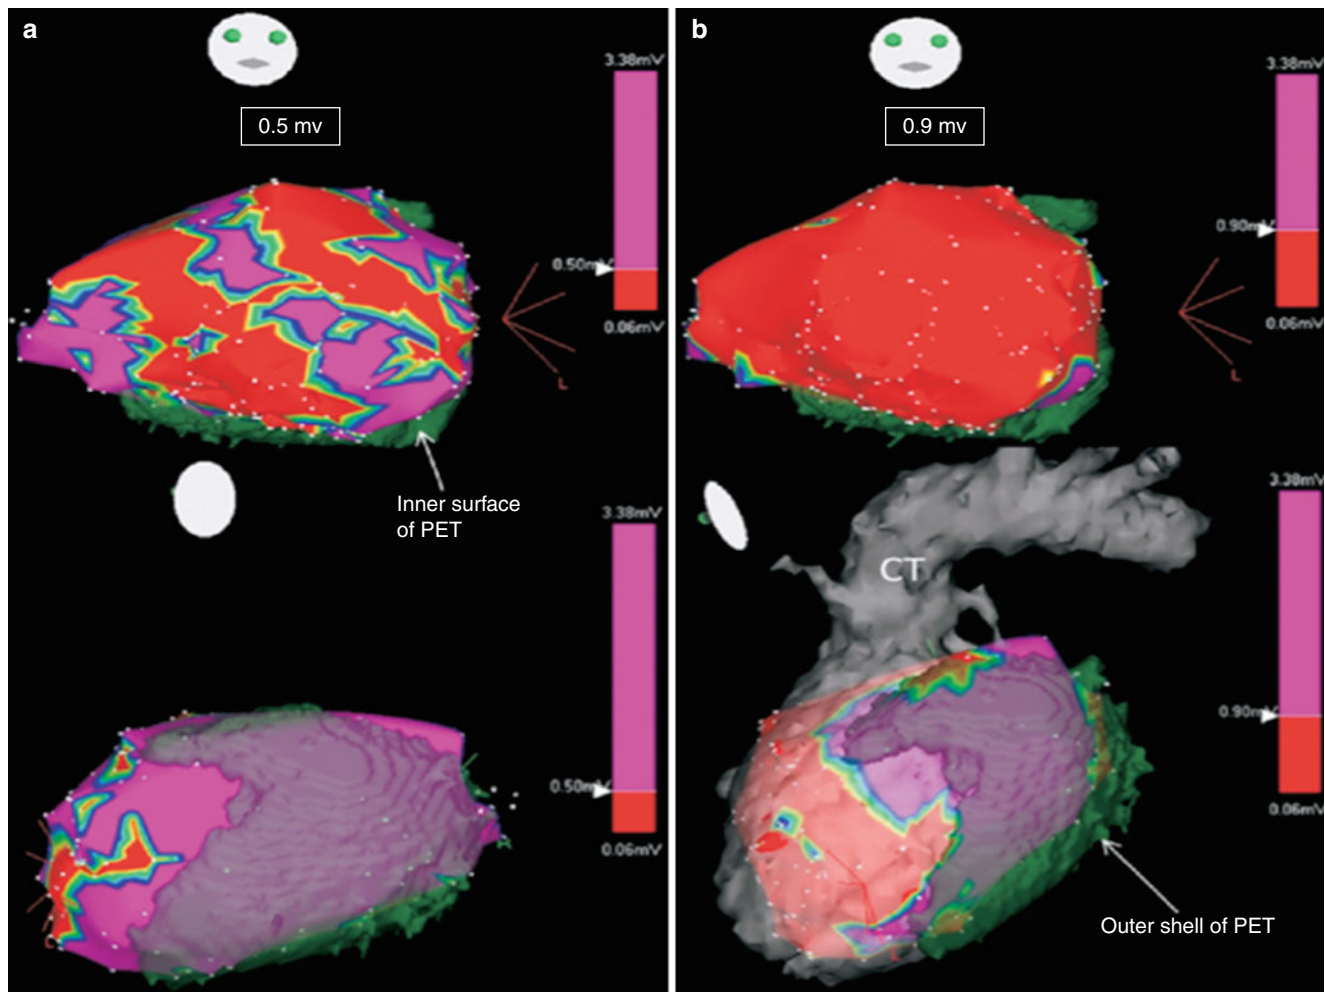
Integration of PET/CT with electroanatomical mapping in a patient with a large scar. (a) Slight left anterior oblique and right post-oblique to demonstrate scar areas at threshold 0.5 mV. (b) Same views
